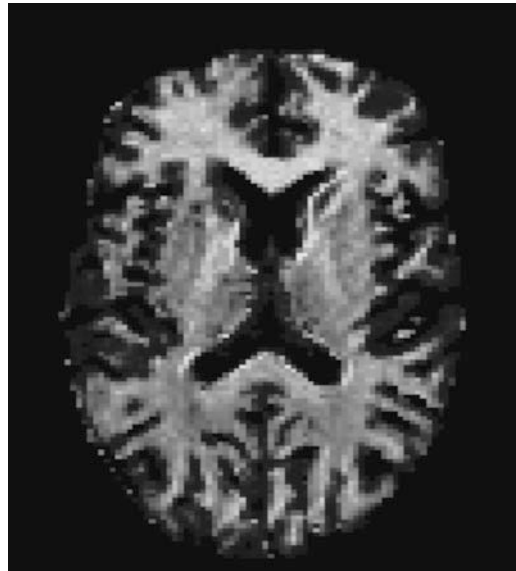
Myelin water fraction map. The myelin-selective magnetic resonance imaging (MRI) techniques reveal the MRI-visible water component associated with myelin
